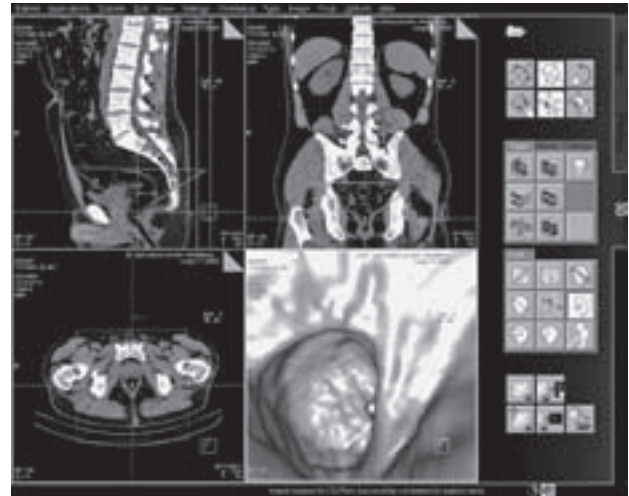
High resolution computed tomography accompanied with VC and 3DVR was performed in the 46-year-old man suffering from colonic cramps. Virtual endocamera was situated within the rectum lumen and its view focused upwards. VC working environment was divided in four windows. Virtual endocamera endoluminal position was shown in three main coordinate planes. Reconstructed endocamera view was presented in the fourth window. Endocamera view was focused in cranial direction within the sigmoid colon. Normal endoluminal appearance as presented by the fly-through procedure was shown.
